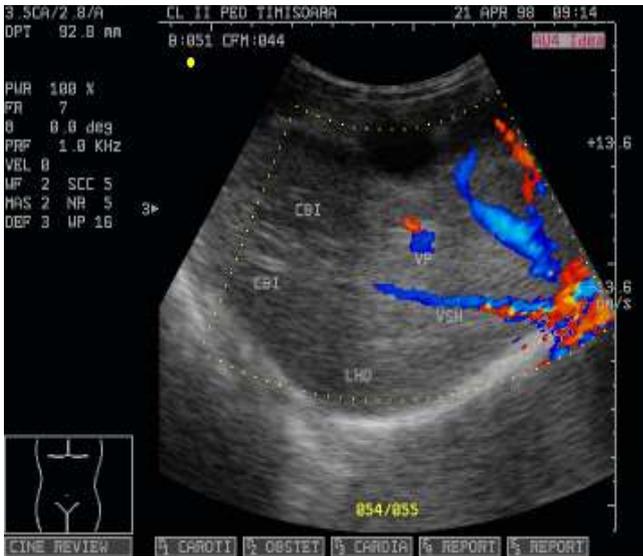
Doppler techniques for the diagnosis of the biliary tract dilatation from the venous or arterial dilatations
